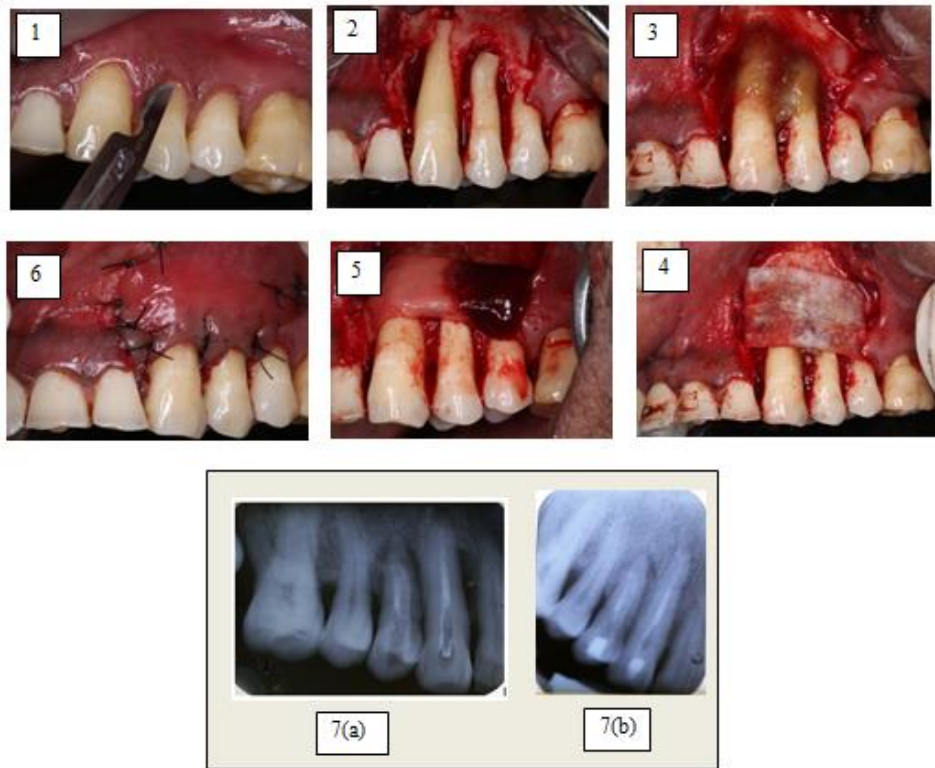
(1) Incision given; (2) Apicetomy cut given; (3) Nova bone putty placed; (4) Collagen membrane placed; (5) PRF membrane placed; (6) Sutures placed; (7a) Immediate post-op intra-oral periapical radiograph; (7b) Intra-oral periapical radiograph after 1 year.
